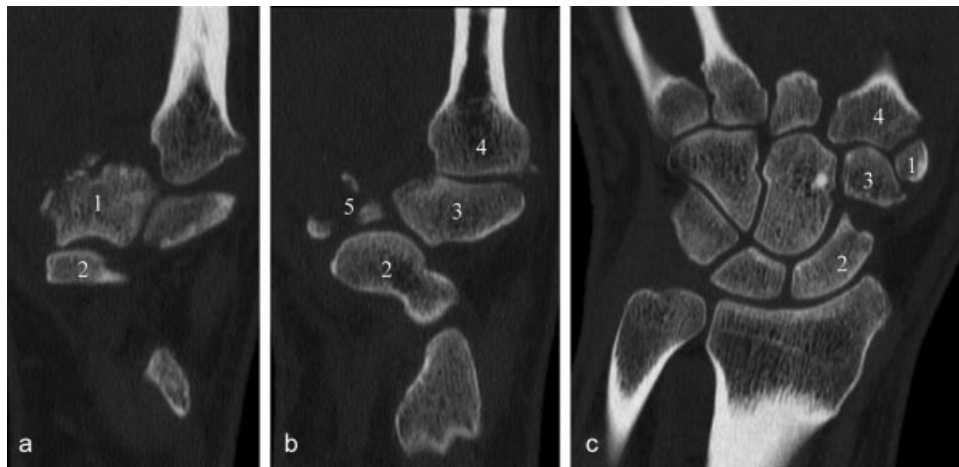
(a) CT scan with sagittal reconstructions of the wrist show subluxation of the trapezium (1) at its articulation with the scaphoid (2). (b) CT scan with sagittal reconstructions of the wrist show dorsal dislocation of the trapezoid (3) at its articulation with the scaphoid (2), maintaining its relationship with the second metacarpal (4). Volar avulsion fractures of the trapezium are visualized (5). (c) CT scan with coronal reconstructions of the wrist show subtle dorsal relationship of trapezoid (3) relative to scaphoid (2).
